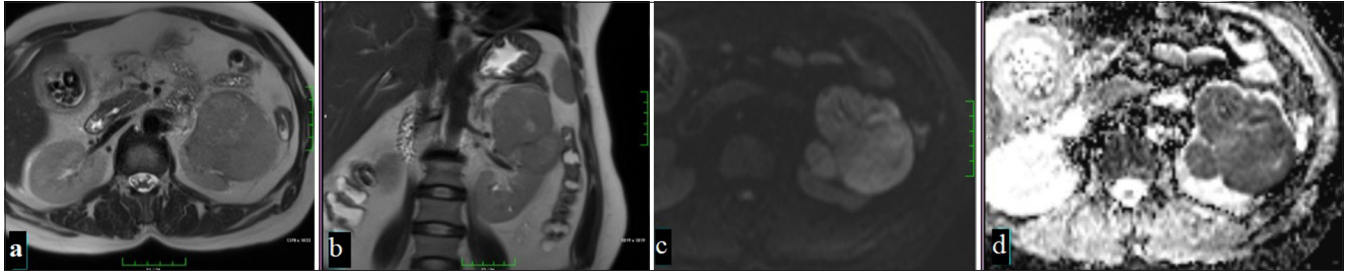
A 53-year-old woman with a mass that is iso-hypointense compared to the renal parenchyma in T2-weighted imaging on axial (a) and coronal (b) planes on MRI, with focal hyperintense areas noted sporadically. The mass is observed to be hyperintense on DWI (c) and shows diffusion restriction suggestive of malignancy on ADC (d) (Chromofobe renal cell carcinoma).
